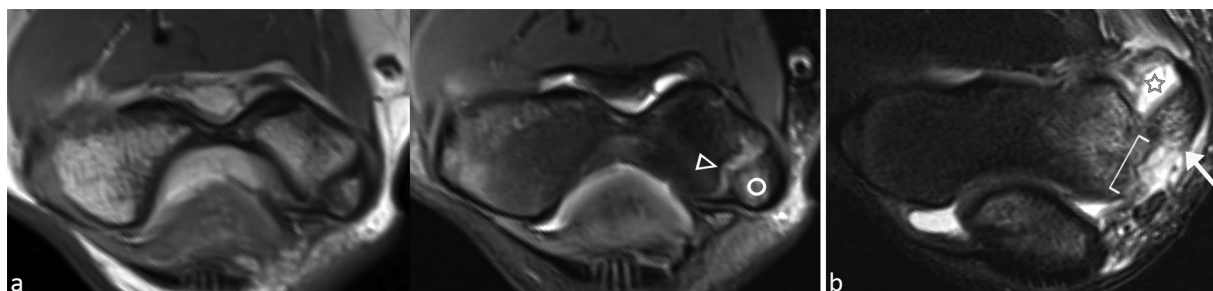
Examples of apophyseal primary periphyseal stress injury (PPSI) and avulsion fracture of the medial epicondyle. (a) Axial intermediate-weighted (left) and T2-weighted fat-suppressed MR (middle) images from a 9-year-old boy show irregularity and widening of the medial epicondyle physis (triangle) and surrounding reactive marrow edema (circle). (b) Axial T2-weighted fat-suppressed MR (right) image from a different 12-year-old boy shows anterior displacement of the avulsed medial epicondyle (arrow) from its donor site (bracket) with more intense reactive marrow edema and an elbow effusion (star).
